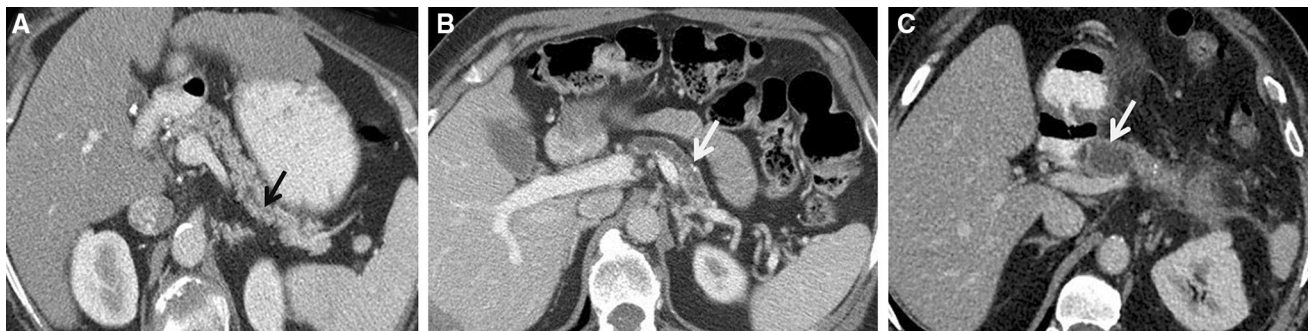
Pancreatic duct caliber: axial CT scan showing PD caliber (arrow) less than 3.5 mm (a), from 3.5 to 7 mm (b), and more than 7 mm (c)
